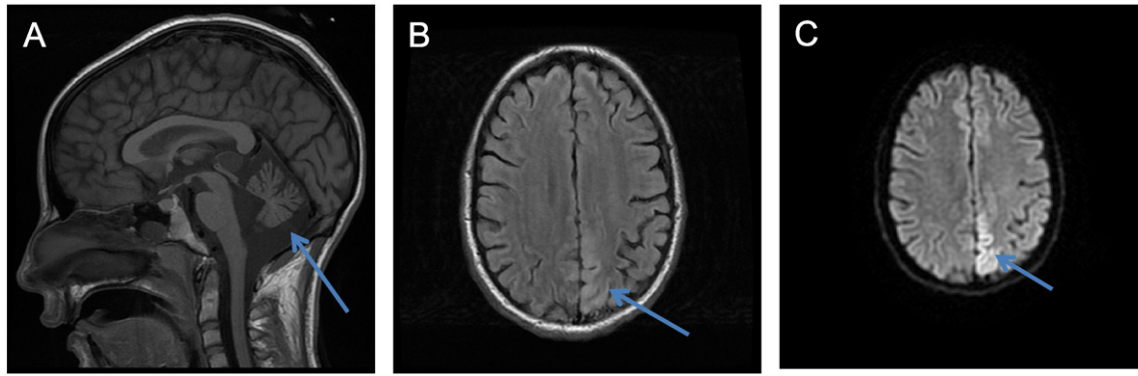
MRI of the brain of Patient 1 with MELAS mutation m.3243A>G. (A) Sagittal T1 demonstrates cerebellar atrophy. (B,C) Axial T2/FLAIR and diffusion weighted imaging shows hyperintensity in the medial left occipital lobe associated with restricted diffusion consistent with a left occipital lobe infarct.
